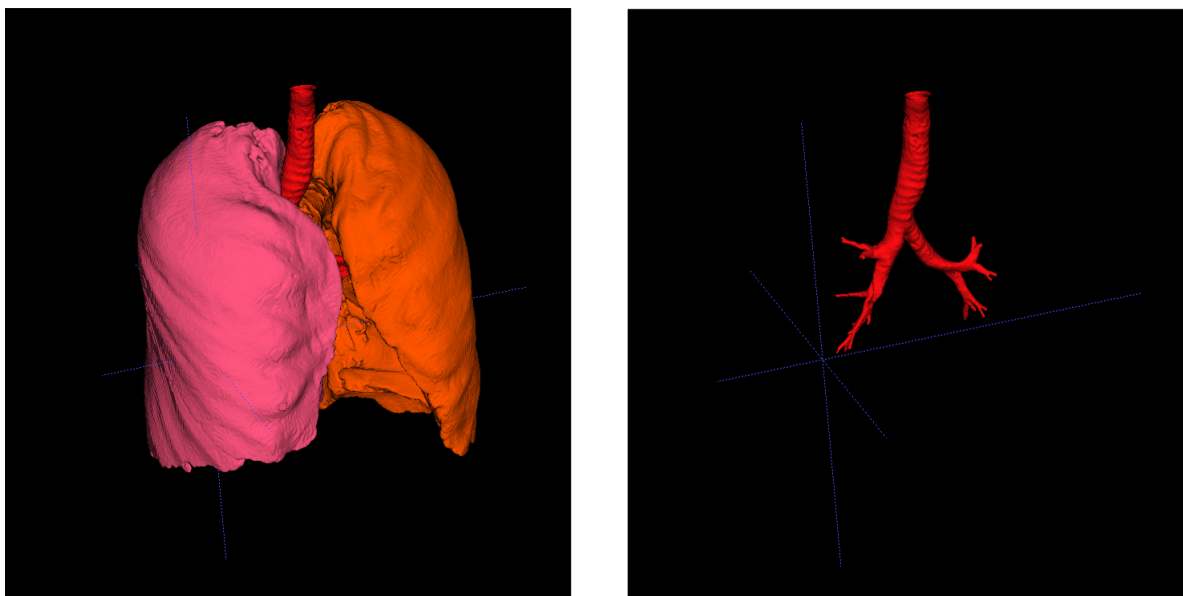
Left: Geometries of the lung’s parenchyma with the first generations of the tracheo-bronchial tree (red). The colors correspond to the right (pink) and left (orange) lungs. Right: Geometry of the first generations of the bronchial tree (around 4 and 5). Geometries are constructed from CT-scan images with the segmentation software ITK-SNAP [54, 141].
